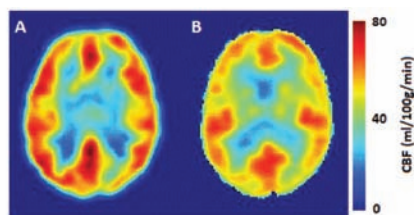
Cerebral perfusion maps measured by (A) arterial spin labelling (CBF = 52.9 ml/100g/min) and (B) the non-invasive hybrid PET/MRI approach (i.e. ¹⁵O-water PET and phase contrast MRI) (CBF = 48.4 ml/100g/min).
